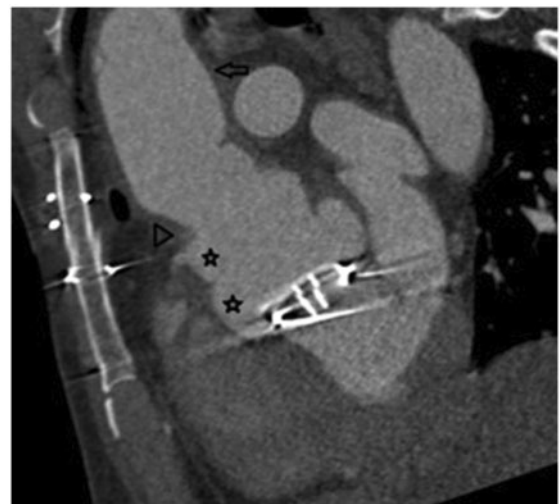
Reconstructed long-axis computed tomography image of the aortic root. Stars indicate the possible sinuses of Valsalva. The one closest to the aortic valve was the false aneurysm. Arrow head shows the proximal suture line of the ascending aortic interposition graft (arrow).
